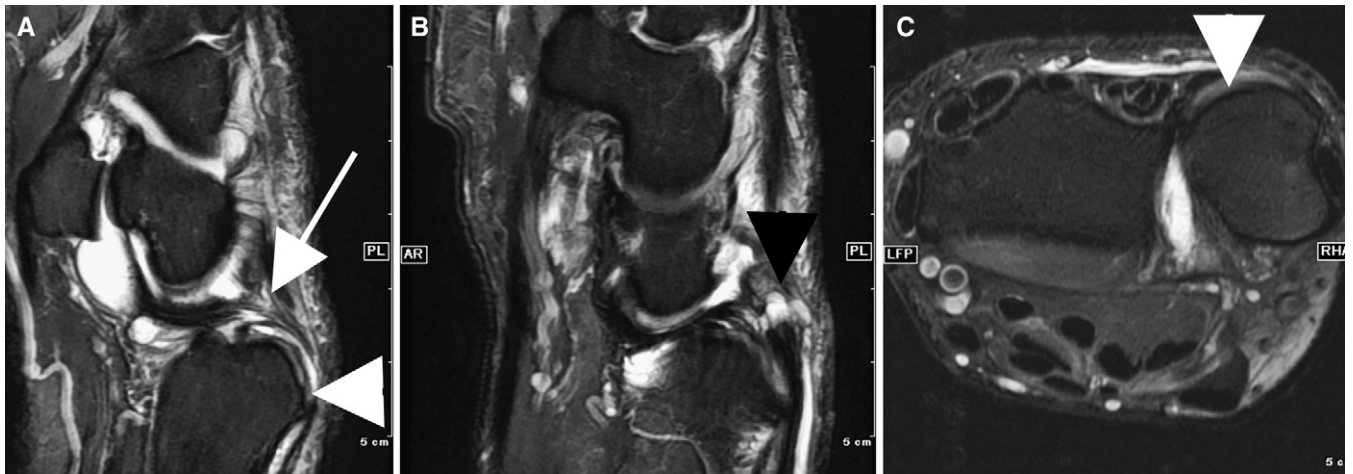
Acute distal radio-ulnar joint subluxation. Sagittal (A, B) and axial (C) proton density–weighted fat-saturated magnetic resonance images, demonstrating dorsal subluxation of the ulnar head (white arrowheads) secondary to surgically proven dorsal radioulnar ligament injury (white arrow), with a ganglion cyst emanating from the ligament (black arrowhead).
